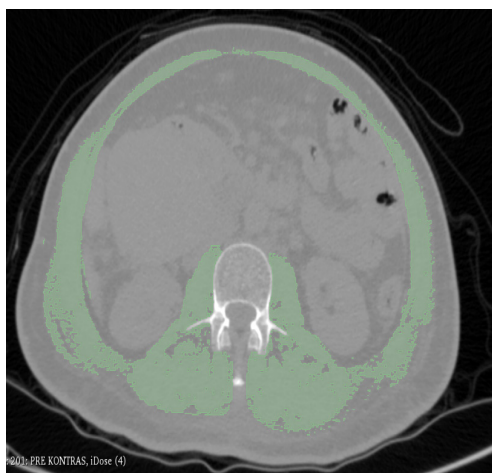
CT scan of a representative case. Cross-sectional areas (cm<sup>2</sup>) of skeletal muscles at the third lumbar level were measured by manual tracing on the CT images, and their sum was calculated. The green area is showing skeletal muscle at the third lumbar level. CT, computed tomography.
